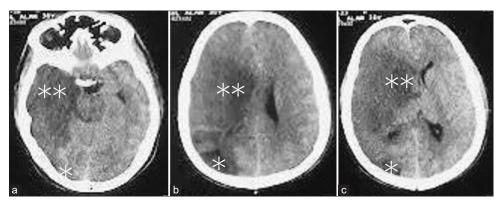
Post operative CT scan showing large right sided MCA territory infarct.
